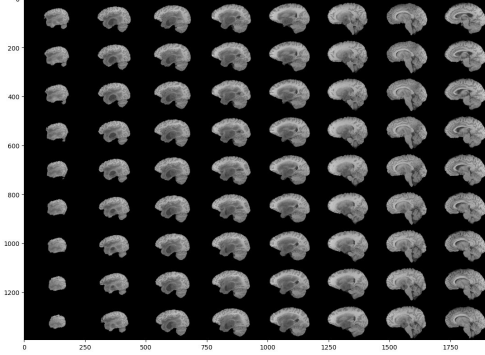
Visualization of Brain MRI Slices shows after preprocessing (resizing, normalization) and augmentation (rotation, flipping, contrast changes).
